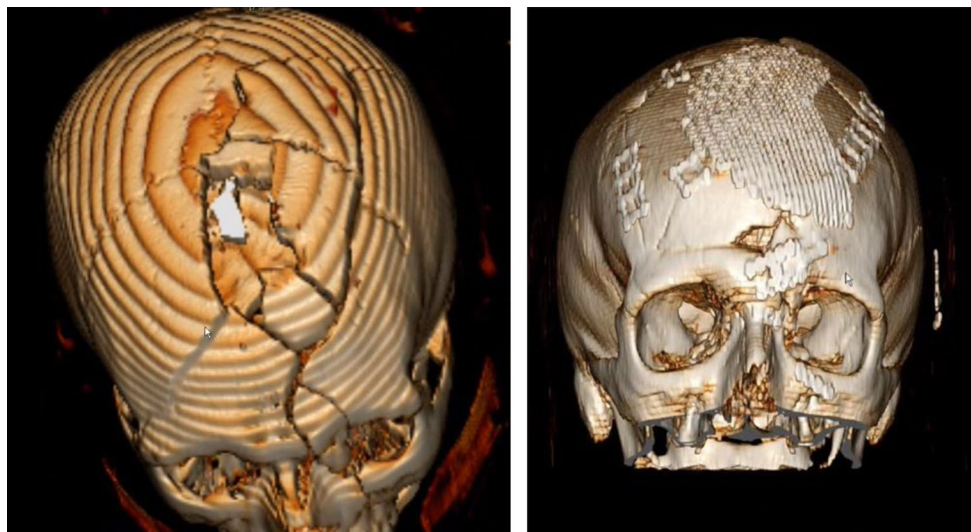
Surface renderings of the skull are shown, based on bone window CT sequences performed acutely (left) and 7 years after the injury (right). The acute CT (left) reveals facial and skull fractures and a penetrating skull wound. These skull fractures and defect were repaired and a graft was placed on the skull in a series of operations (right), including open reduction and internal fixation of the facial fractures, cranialization of the frontal sinus, pericranial flap reconstruction of the skull defect, and titanium mesh cranioplasty
